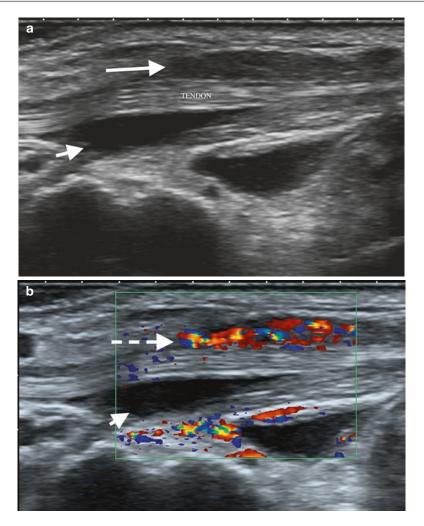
Fourth extensor compartment tenosynovitis of the wrist on ultrasound: (a) tendons surrounded by fluid (anechoic, *short arrow*) and soft tissue thickening/
